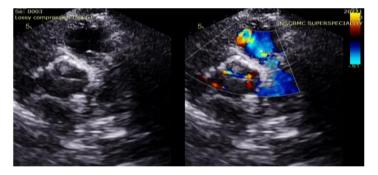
Postoperative ECHO (parasternal short axis view) showing VSD patch with no residual shunt
